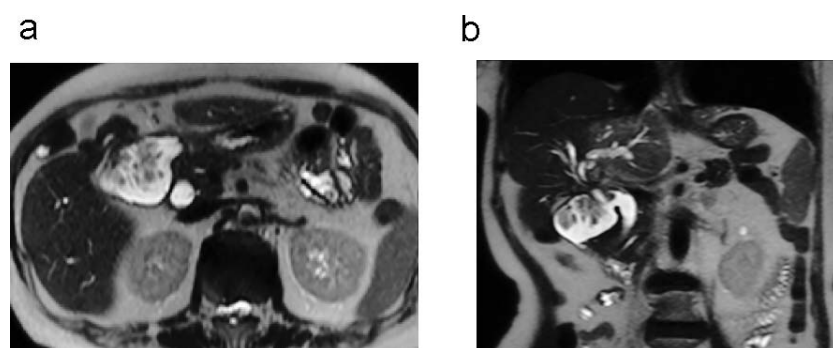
Magnetic resonance imaging (MRI) findings. MRI revealed the connection of the duodenum and hilar bile duct, and duodenal carcinoma was detected in a T2-weighted image. Axial view (a) and coronal view (b).
